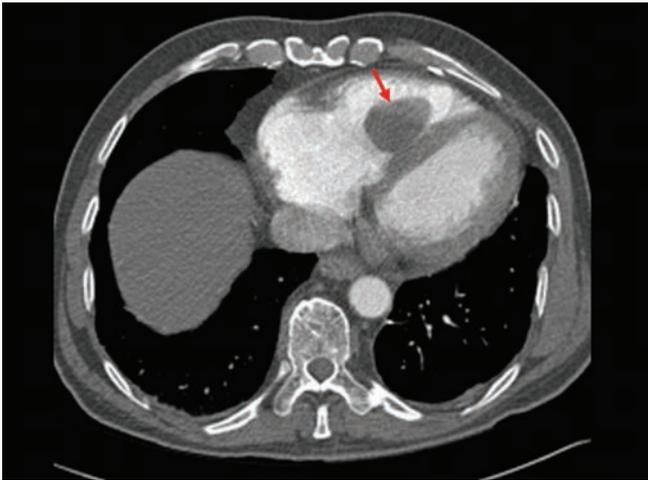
CT chest that demonstrated the right ventricular neoplasm (arrow) with attachment to septum.
